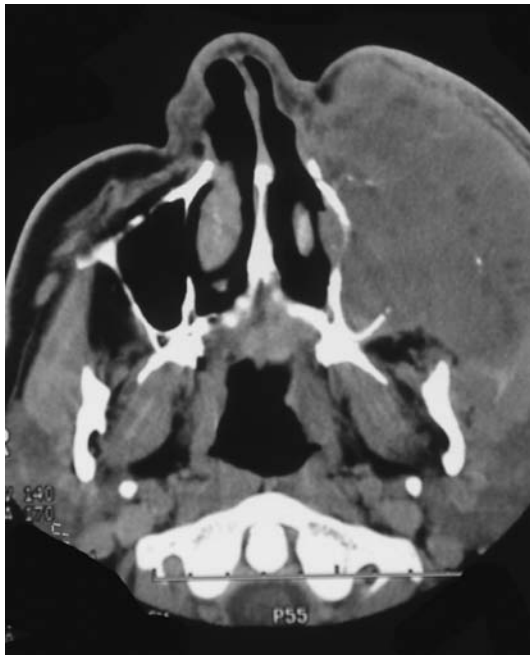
An MRI of a 49-year-old man with massive squamous cell carcinoma arising from an inverting papilloma in the left maxillary sinus.
